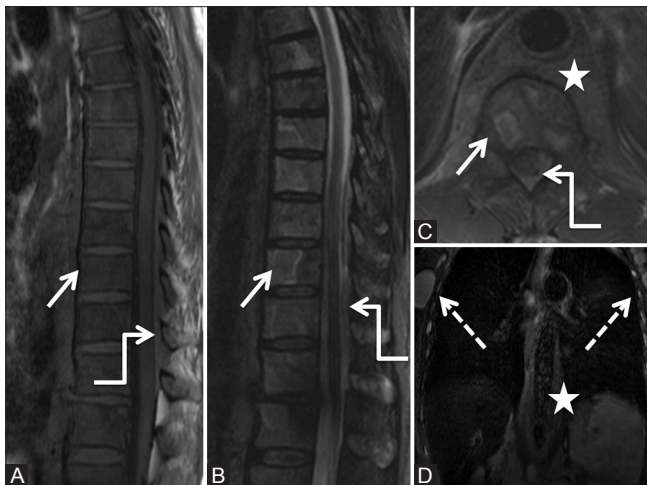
(A-D): Malignant: Lymphoma: 60-year-old male with back pain. Sagittal T1 (A), short T1 inversion recovery (STIR) (B), axial T2-weighted (C), and Coronal STIR (D) images of the thoracic spine show abnormal marrow signal appearing hypointense on T1-weighted images and heterogeneous with focal hyperintense lesions on STIR images in vertebral bodies (arrow) as well as spinous processes. Large paravertebral soft tissue (star) is seen with extension into posterior epidural space (elbow arrow) and causing compression of spinal cord. Note enlarged bilateral axillary lymphadenopathy (dashed arrows). Biopsy was suggestive of non-Hodgkin's lymphoma
